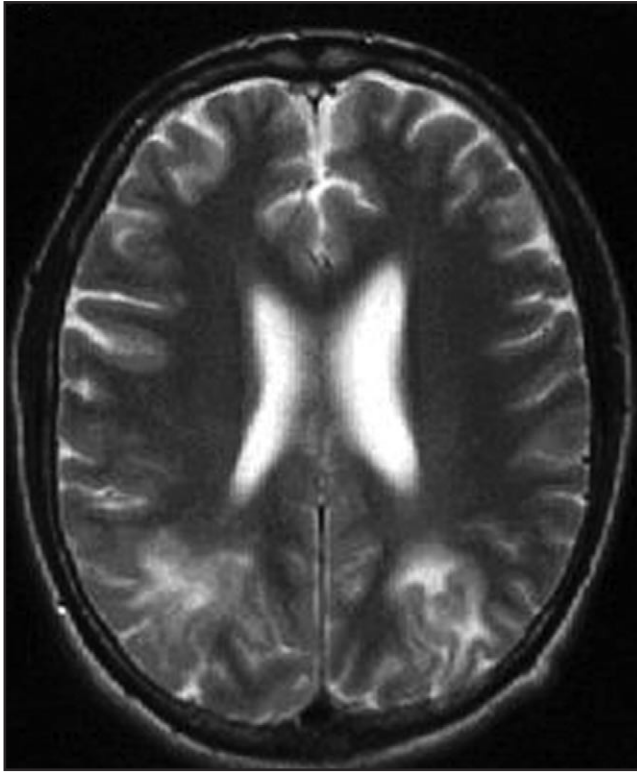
This T2-weighted magnetic resonance image shows hyperintense signal abnormalities in the white matter of the parieto-occipital lobes due to progressive multifocal leukoencephalopathy.
